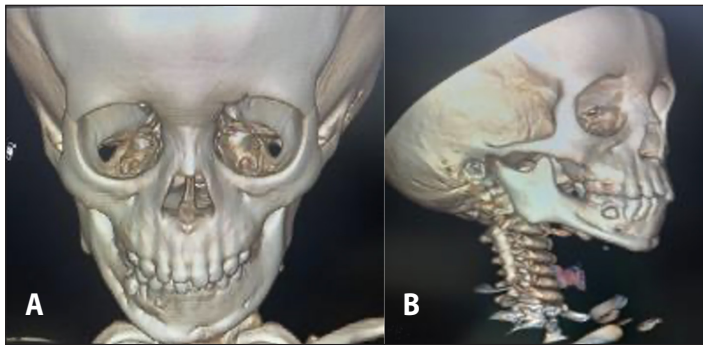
Facial CT scans, 3D reconstruction. A. anterior and B. right lateral oblique views showing longitudinal groove along the body signifying post infection changes.
